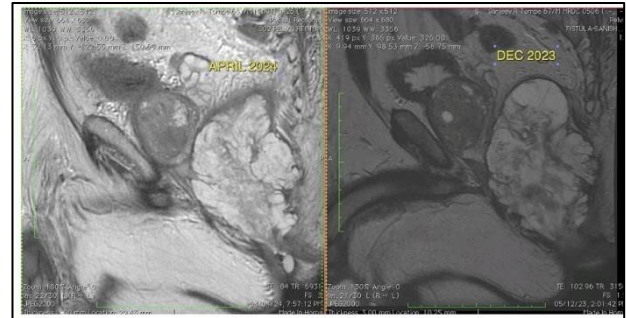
MRI showing size of growth before and during chemotherapy.
